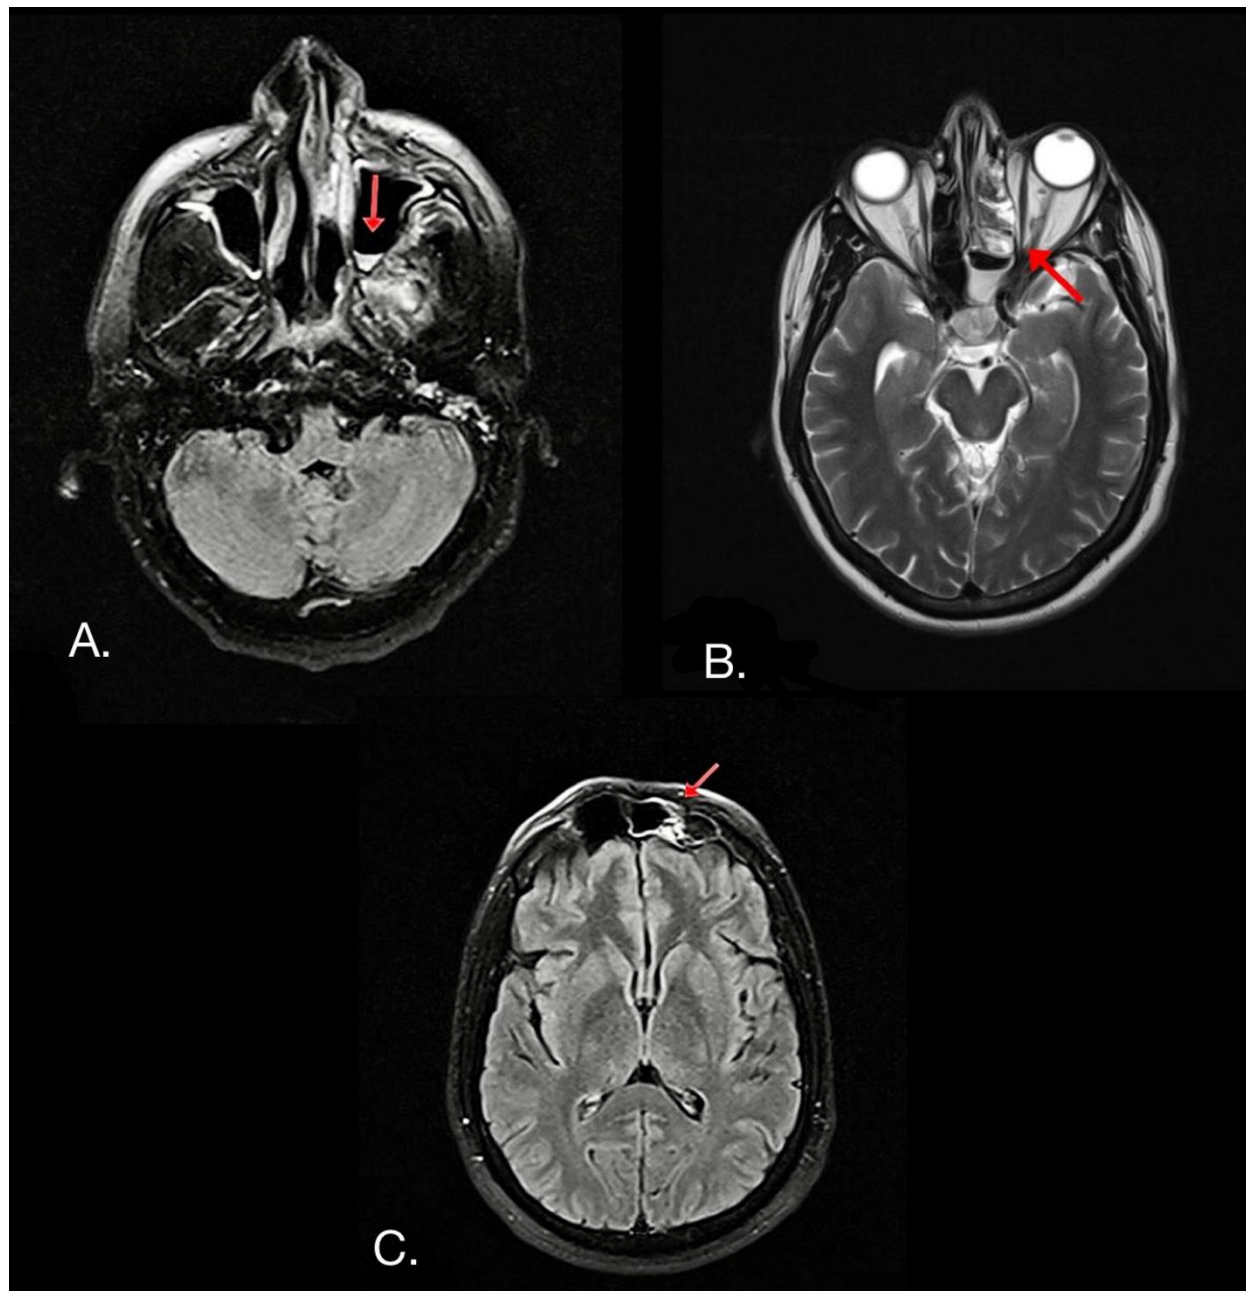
MRI CONTRAST OF PARANASAL SINUS (T2 FLAIR/HYPERINTENSITY)
